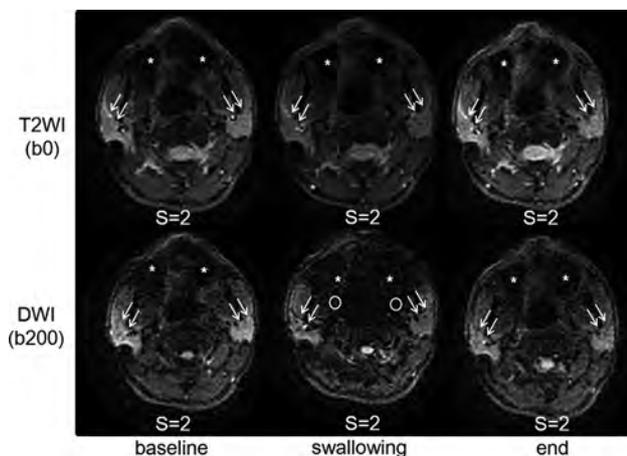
Magnetic susceptibility artifacts on T2WI and DWI. Mild distortion and signal loss involving the bilateral maxillary sinuses (*stars*) occur on all T2WI and DWI scans. During swallowing, the parotid glands are still free from artifacts, though more extensive artifacts involve the nasal cavity, oropharynx, and bilateral masticator spaces (*circles*). The anterior margins of the parotid glands are indicated by *arrows*. S indicates magnetic susceptibility artifact score.
